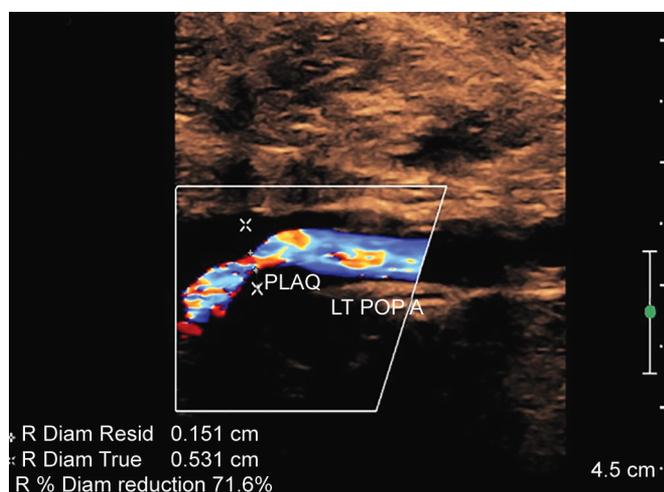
Doppler study of a 68-year-old male postcoronary artery bypass grafting, known hypertension, and known diabetes of 17 years’ duration. Left popliteal artery showing plaque with 71.6% luminal reduction
